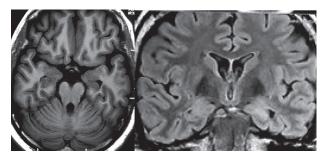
MRI Brain showing hippocampal atrophy
